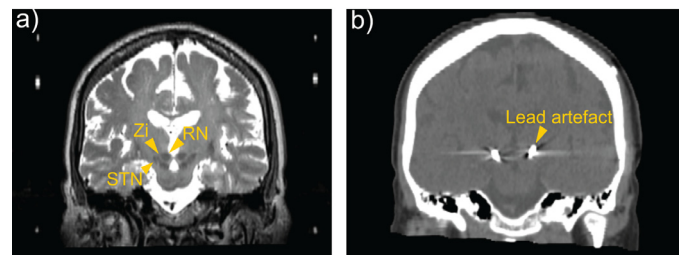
View of the region of interest for the analysis. (a) Pre-operative coronal T₂ slice where Red nucleus (RN), Zona incerta (Zi) and the subthalamic nucleus (STN) is highlighted and (b) post-operative CT where the artefact from the DBS lead is visible.
